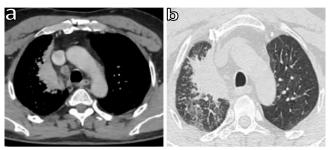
Thoracic computed tomography (CT) in mediastinal and parenchymal windows reveals a tumor process affecting the ventral segment of the upper right lobe, measuring 8 cm in size. The mass exhibits irregular contours, indicating an aggressive process
